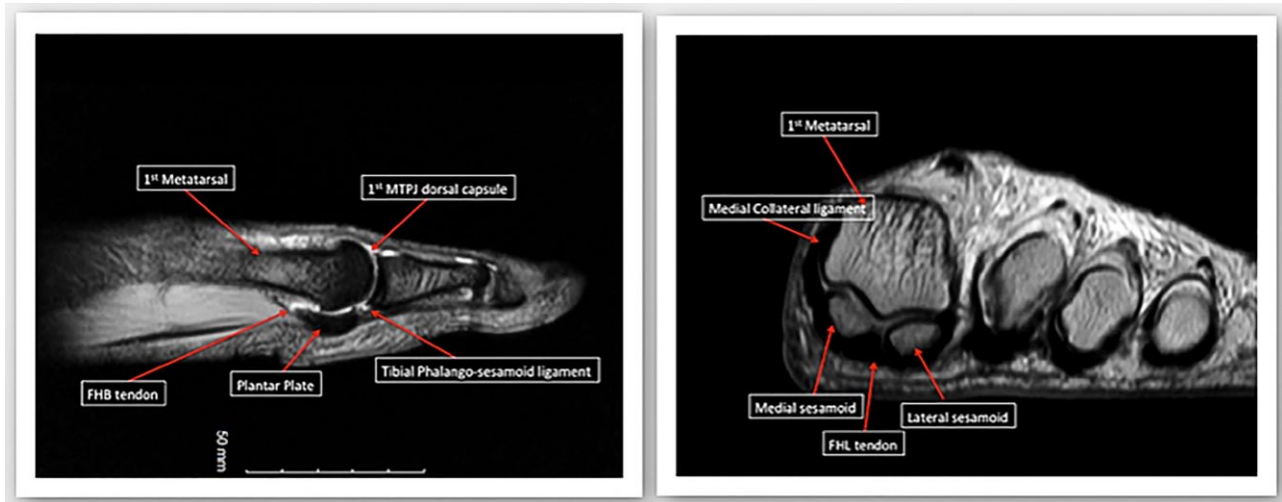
Normal MRI images of the first MTP joint. The left image shows a sagittal T2 image and the right is a proton density-weighted coronal image. The plantar plate is the greatly thickened plantar capsule. The hallux MTP joint is dynamically stabilized by the short flexor complex (the FHB and the sesamoids embedded in the FHB tendons), the adductor hallucis and the abductor hallucis tendons. The FHB tendon inserts on the proximal phalanx in confluence with the plantar plate. As the FHB moves distally toward its insertion, the tendon envelops the medial (tibial) and lateral (fibular) sesamoids. The flexor hallucis longus tendon courses plantar to the metatarsal head, between the sesamoids in a separate sheath.
